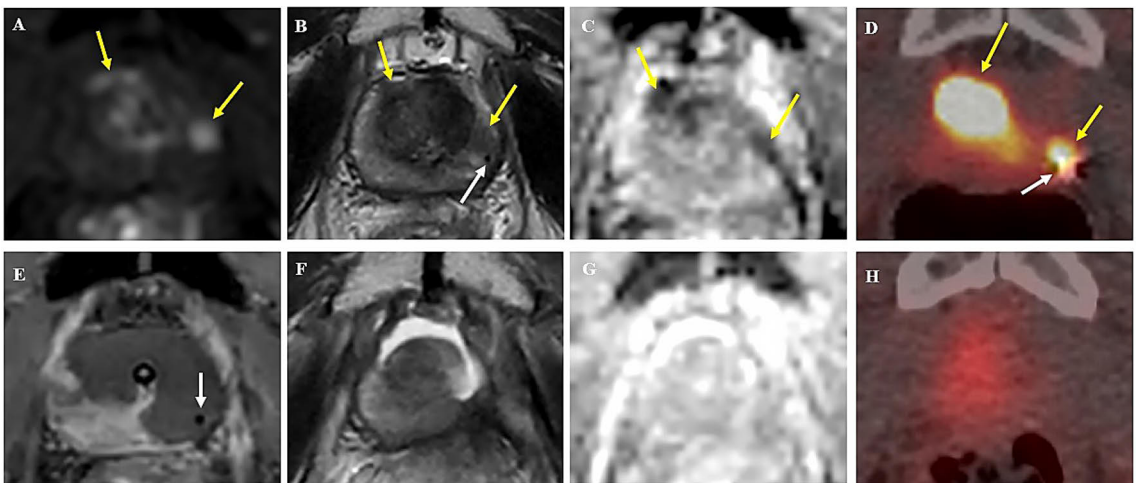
(A–D) Baseline imaging of a patient, with radiorecurrent right anterior and left lateral mid-gland tumor foci. (A) Yellow arrows indicate early enhancement, (B) T2 hypointensity, and (C) restricted diffusion on baseline MRI. (D) Baseline PSMA-PET-CT revealed significant uptake in regions concordant with MRI-visible PI-RR 5 lesions. (B, D, E) Fiducial marker is visible in the near vicinity of the left tumor (white arrow). (E) Immediately after treatment, the NPV reached to the capsule in both tumor locations. (F) At 12 months, MRI shows a fluid-filled cavity and (G) no diffusion restriction in the treatment area, and (H) PSMA-PET-CT shows no intensive focal uptake. The marker had also disappeared. (From original publication II)
